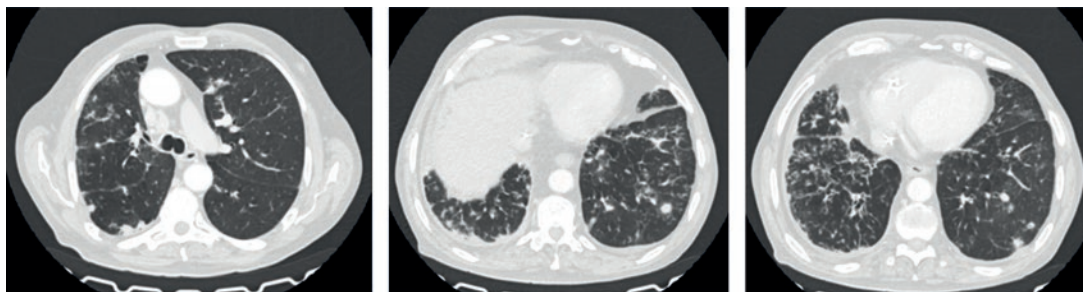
Computed tomography scan showing bronchiolitis obliterans related to chemotherapy.
